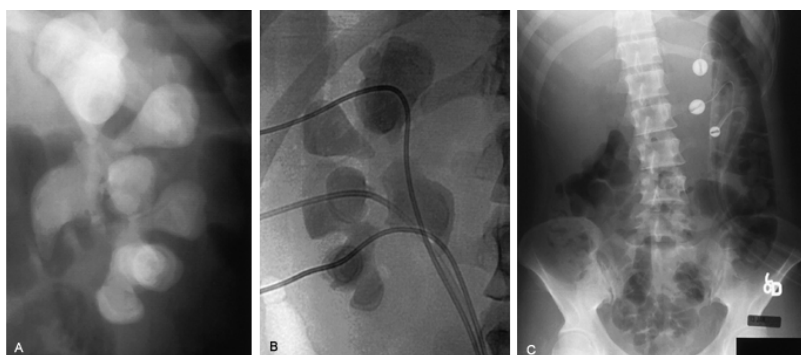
A: Plain film in this 22-year-old woman with recurrent proteus urinary infection reveals a complete, fully branched staghorn calculus overlying the left kidney. B: Reverse fluoroscopic view of percutaneous access via three tracts. C: Plain film from follow-up nephrostogram shows complete resolution of the stones.
